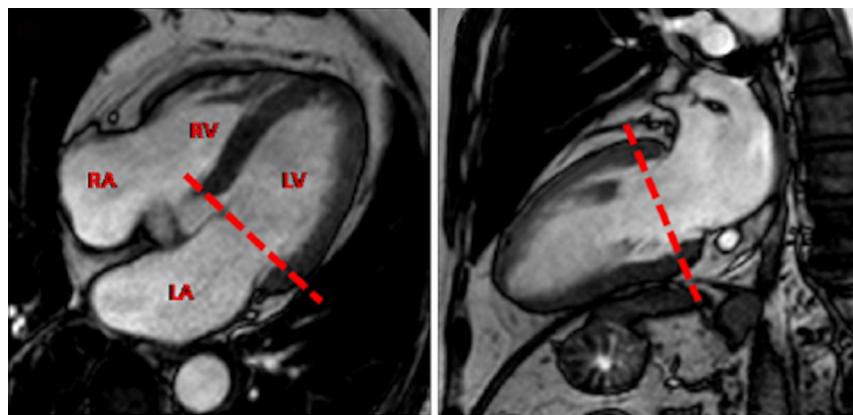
Example of the recommended planned situation for the series (these images are provided by courtesy of Ricardo Duarte and Gabriel Fernandez "Assessment of LV DF by MRI")
